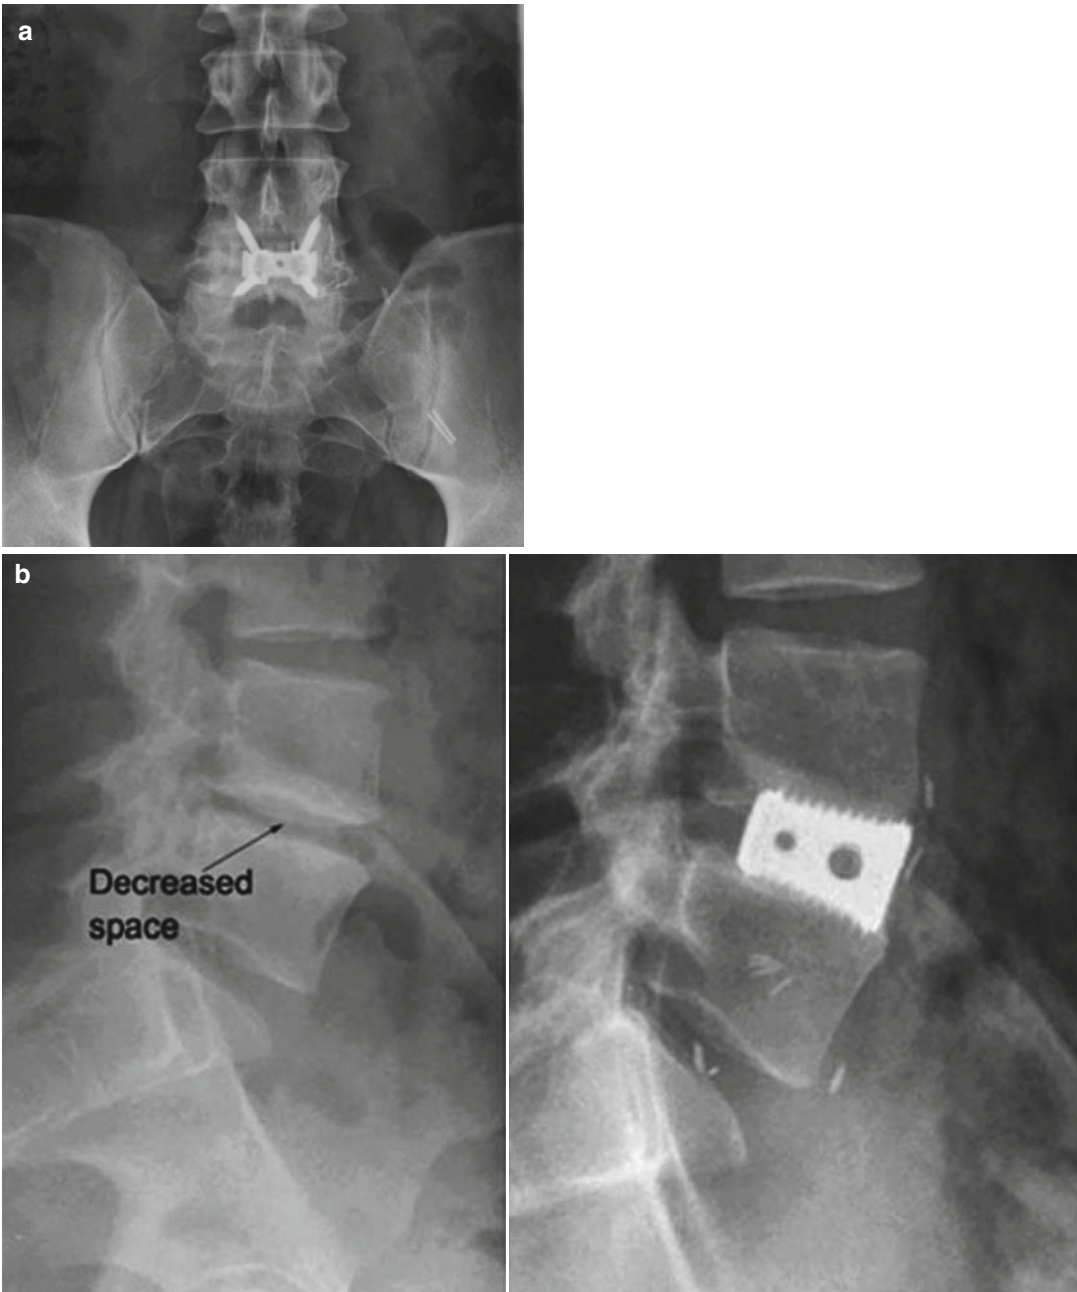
(a) This is a postoperative radiograph showing instrumentation for anterior lumbar interbody fusion with an intervertebral cage. (b) The image on the *left* is a lateral preoperative radiograph showing decreased disc space between L4 and L5 vertebrae. The image on the *right* is a postoperative radiograph of an interbody cage inserted with an ALIF procedure. The bone graft
